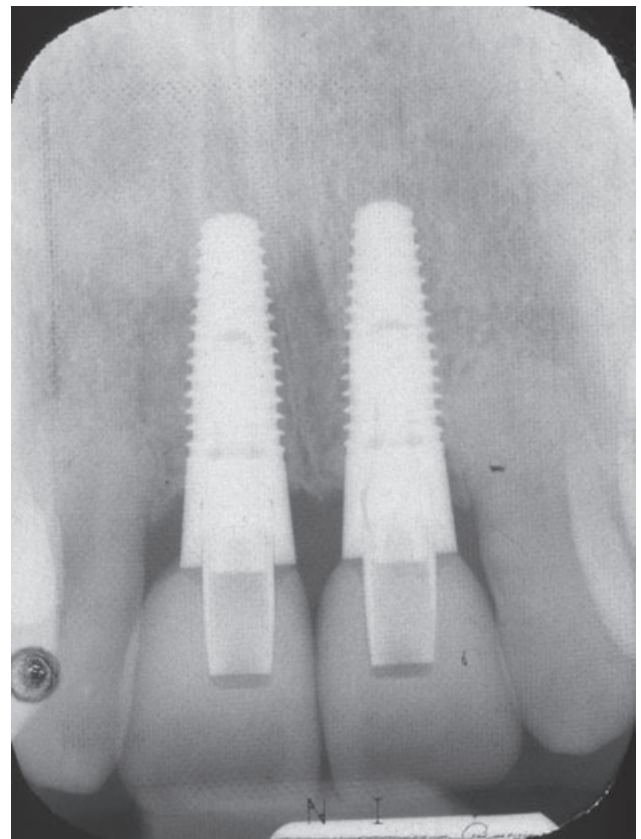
Radiographic view at 12 months postsurgery. Note resorption of interproximal bone peaks.
